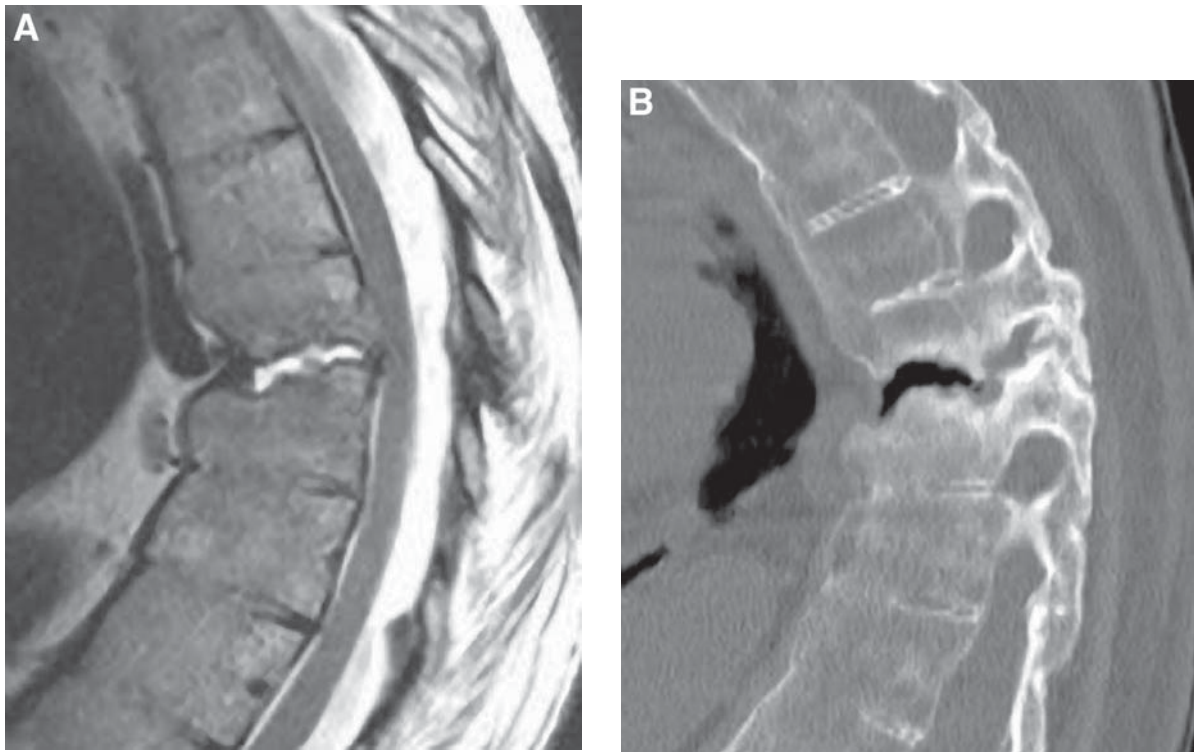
(A) Sagittal T2-weighted image demonstrates fluid in the expected location of the T8–9 disc space with associated endplate erosion. This appearance could be misconstrued as indicative of discitis. (B) Sagittal CT reformation more clearly shows the bony fusion characteristic of ankylosing spondylitis, which in this case is complicated by fracture and pseudoarthrosis. Patients with DISH are at risk for similar injuries. Note again the association of a vacuum cleft with high T2 signal on MR.
